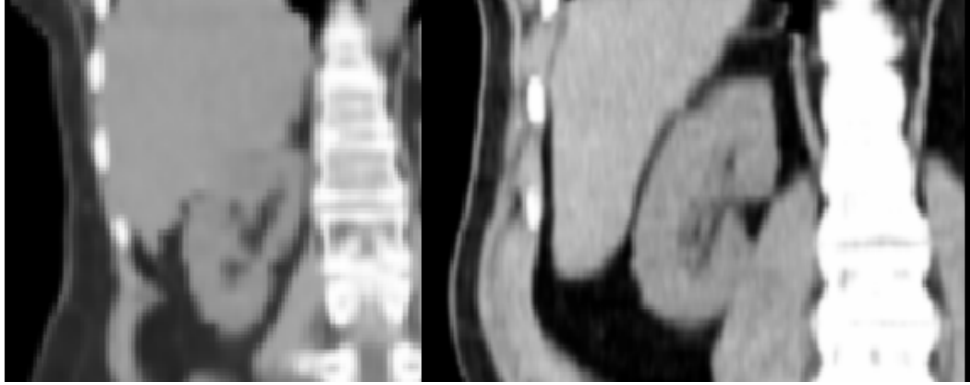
Corresponding coronal CT slices of two human abdomens. The liver, in the upper left of each patient image, has a widely disparate correspondence with the nearby kidney. This variability poses a challenge in constructing an effective image match function for prospective kidney segmentations.
